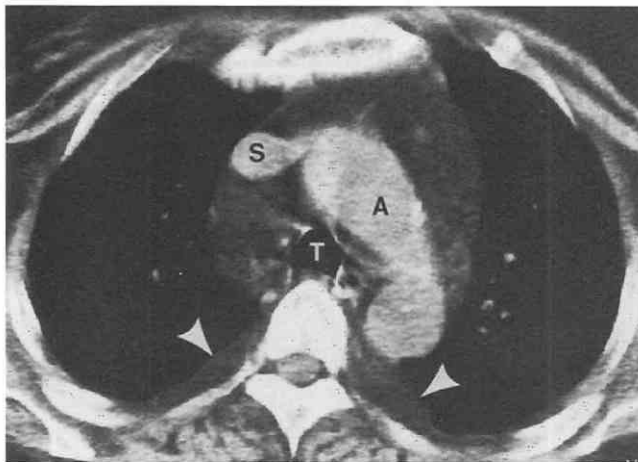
Mediastinal lipomatosis. CT shows bilateral mediastinal widening caused by mediastinal fat deposition. Fat deposition is also visible in the paraspinal and posterior pleural regions bilaterally (arrowheads). The distribution is typical of mediastinal lipomatosis. A, aorta; S, superior vena cava; T, trachea.
